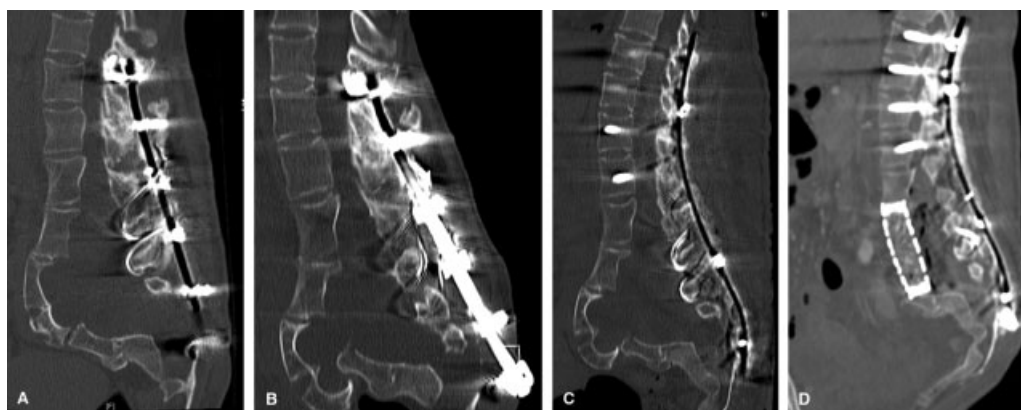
Sagittal computed tomography scans from (A) 2008 and (B) 2013 revealing osteoporosis with progressive spondyloptosis toward the lesser pelvis. (C) After removing the Harrington system, a low-profile fixateur was implanted. (D) After gathering the meningocele, resection of the lumbar vertebrae L2–L4 with subsequent implantation of an anteflexed titanium mesh (100 × 17 × 22 mm) was performed.
